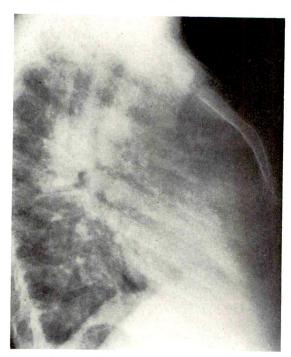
Case III. Lateral roentgenogram of the sternum at  $4\frac{1}{2}$  years of age. All of the mesosternal segments and manubrium are now fused into a single bone.
